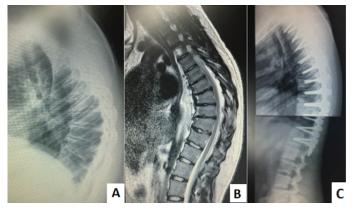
A – Lateral X-ray of the thoracic spine preoperative, showing a curvature from T2 to T12 of 67°. B – Preoperative MRI of the thoracic spine, showing multiple disc involvement and wedging of the thoracic vertebrae. C – Postoperative thoracolumbar X-ray following posterior spinal fusion, demonstrating correction of the curvature to 36°.
